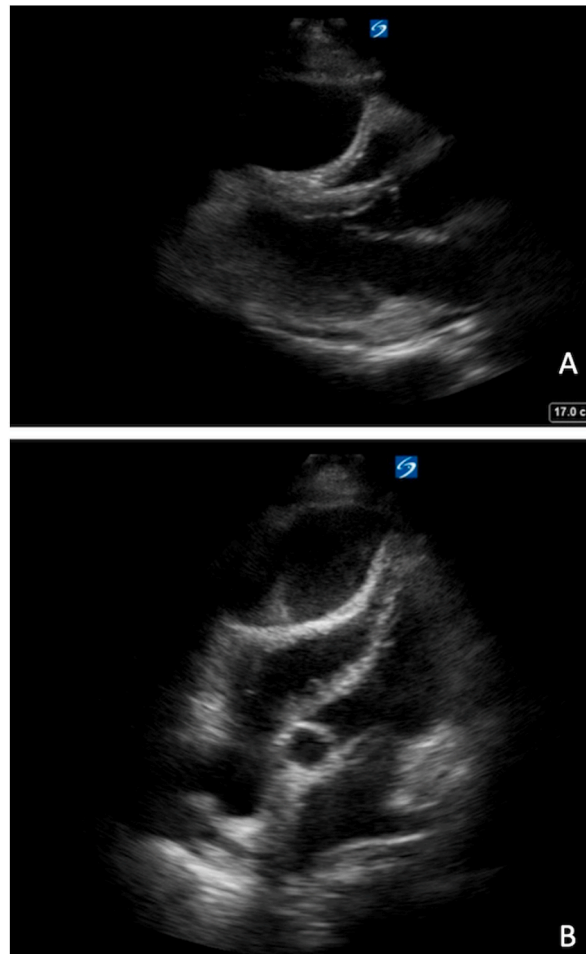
Point of Care Ultrasound (POCUS) demonstrating right ventricular collapse and constriction with loculated pericardial effusion (A-parasternal long axis; B-apical five chamber view).
